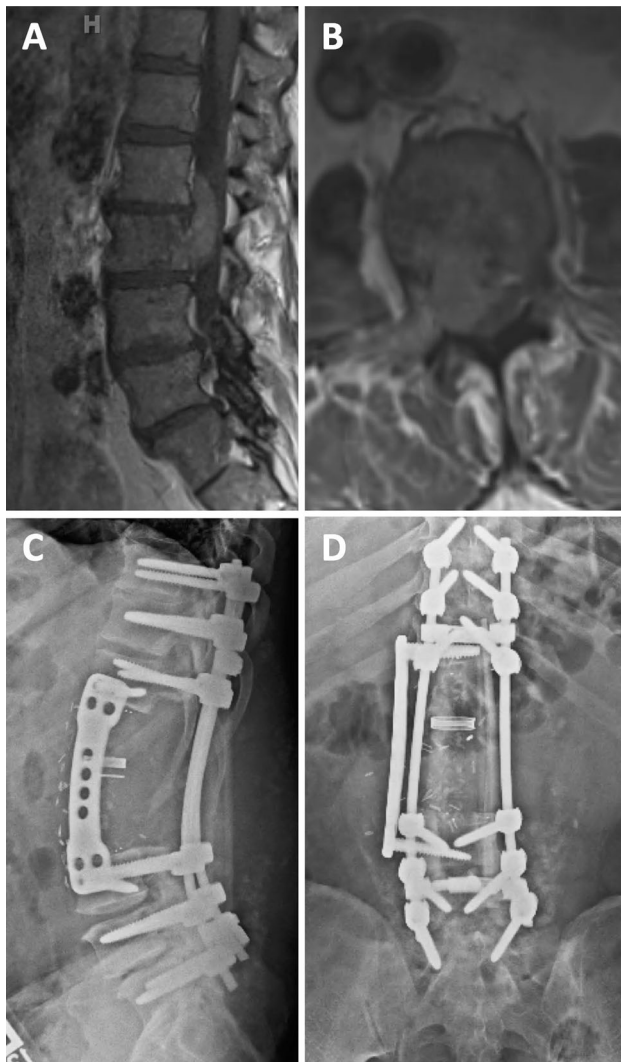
A 70-year-old male presented with a 4-month history of low back and right thigh pain. MRI revealed a lesion originating from the L2 vertebral body (a) and extending rostrally behind the L1 vertebral body; the tumor also extended into the spinal canal, causing significant neural compression (b). The patient underwent CT-guided biopsy, which was consistent with chordoma. Preoperatively, he received stereotactic body radiotherapy (1800 cGy to the 67 % isodose line given in three fractions). A TES was performed at the L1 and L2 levels, and anterior reconstruction was made using a distractible PEEK cage and plate (c and d). The patient is currently disease-free at 33 months of follow-up (Department of Neurosurgery, Johns Hopkins University School of Medicine)
